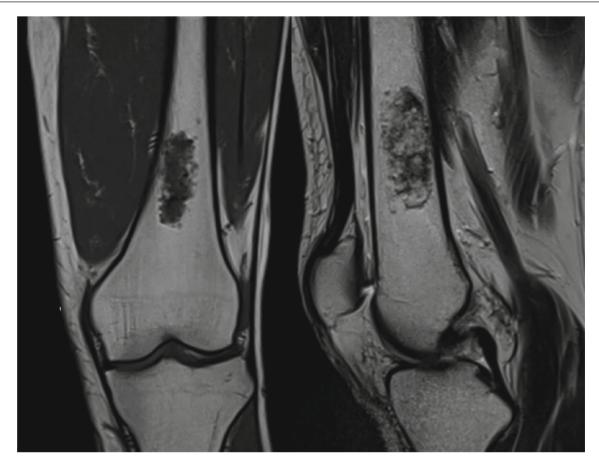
Same case as Fig. 7.2:. coronal and sagittal T1 MRI sequence showing a cartilaginous tumor of 2×4 cm without any cortical compromise nor soft tissue mass
